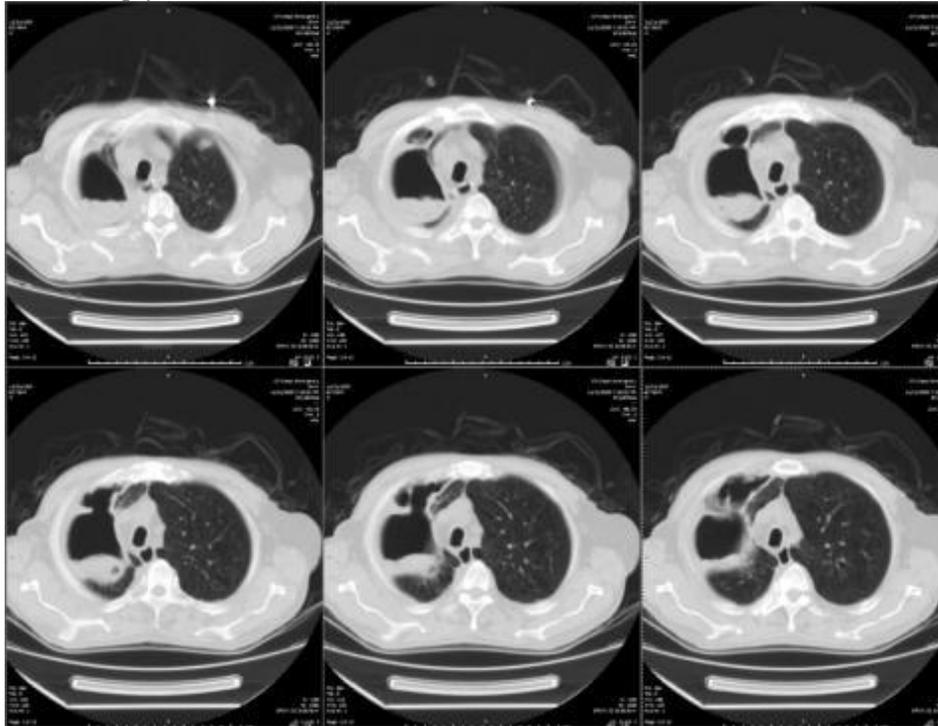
Axial chest CT lung window revealed a right apical cavitory lung lesion with an area of soft tissue density which likely represents the aspergilloma.
